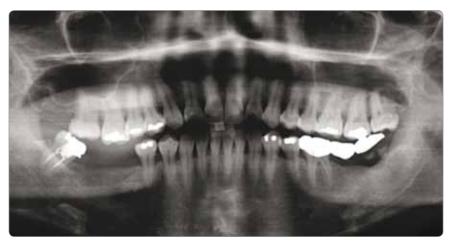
Pre-op radiography
